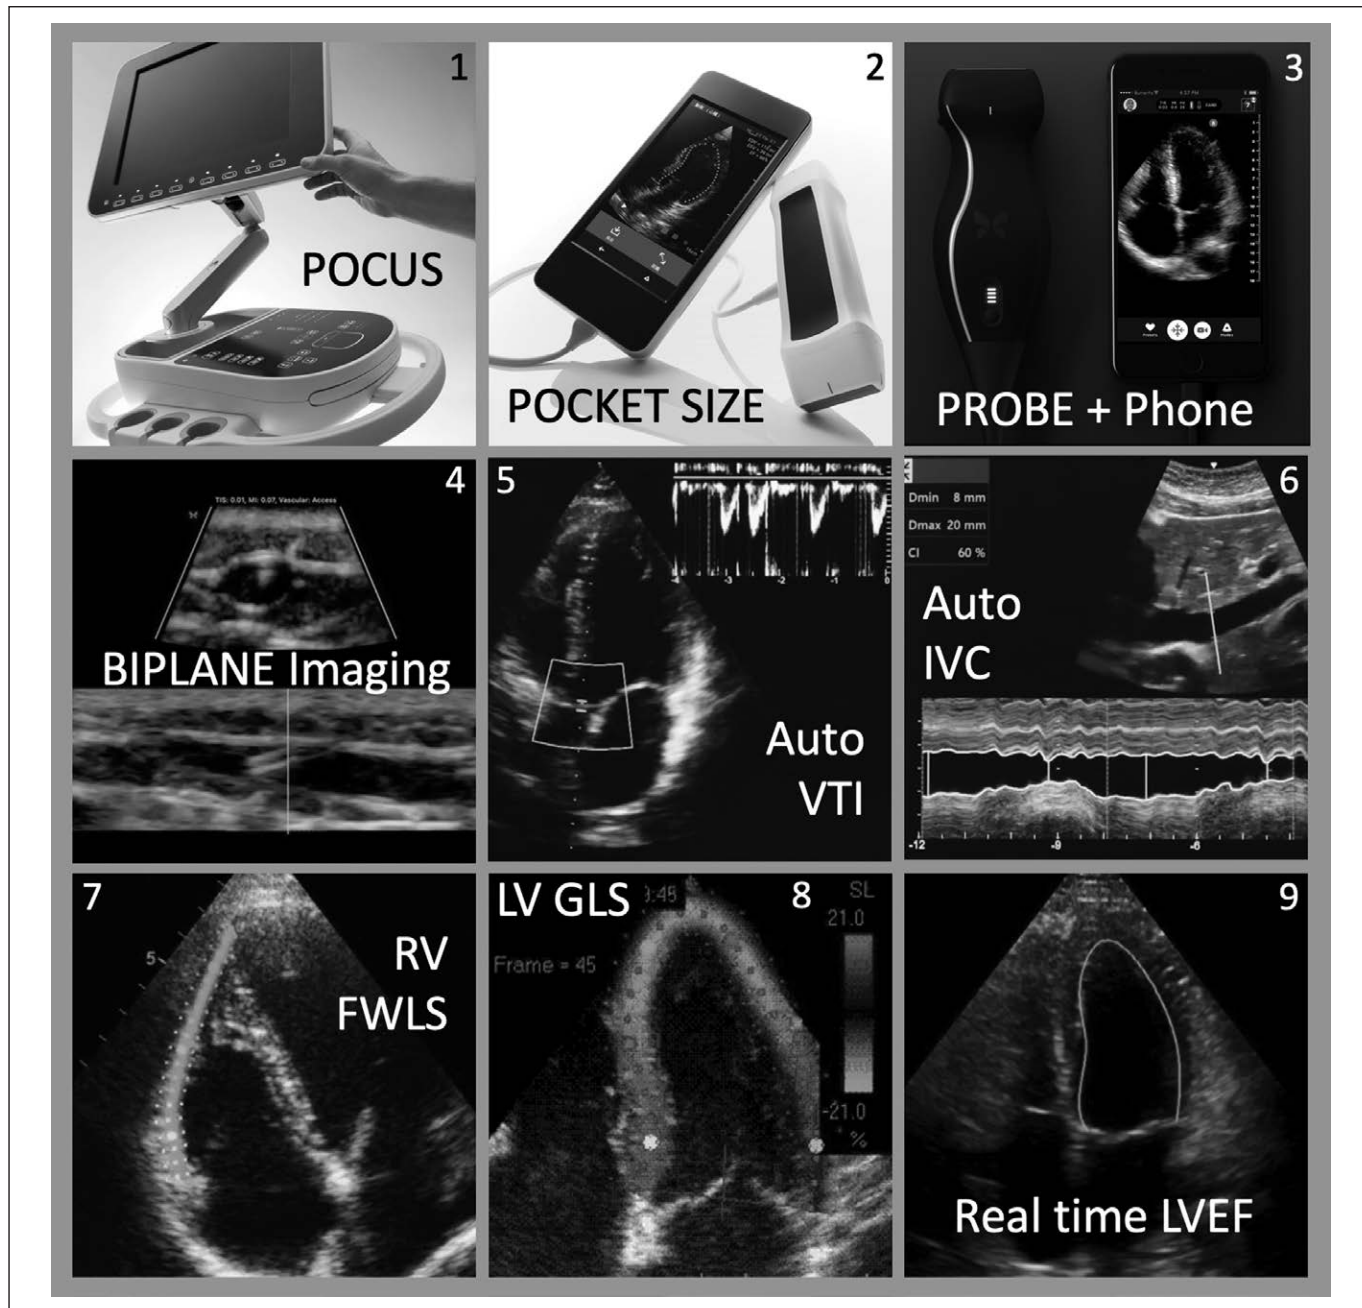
Examples of hardware and software innovations contributing to the rise of point of care ultrasound (POCUS) evaluations in critically ill patients, in particular those with coronavirus disease 2019 (1). Light and easy to move POCUS system used by Chotalia et al (4), from Philips Healthcare (Andover, MA) with permission; (2) pocket size echo-Doppler device, from GE HealthCare (Chicago, IL) with permission; (3 and 4) on-chip digital microbeamforming probe to be connected to a smartphone, enabling the simultaneous visualization of a transversal and longitudinal view to facilitate vascular access, from Butterfly Network (Guilford, CT) with permission; (5 and 6) software enabling the automatic measurement of the subaortic velocity time integral (VTI) and of the inferior vena cava (IVC) diameter respiratory variations; (7 and 8) speckle tracking software enabling the automatic quantification of the right ventricular free wall longitudinal strain (RV FWLS) and of the left ventricular global longitudinal strain (LV GLS) which are markers of myocardium shortening; (9) machine learning-enabled real-time measurement of left ventricular ejection fraction (LVEF), from GE Healthcare with permission.
